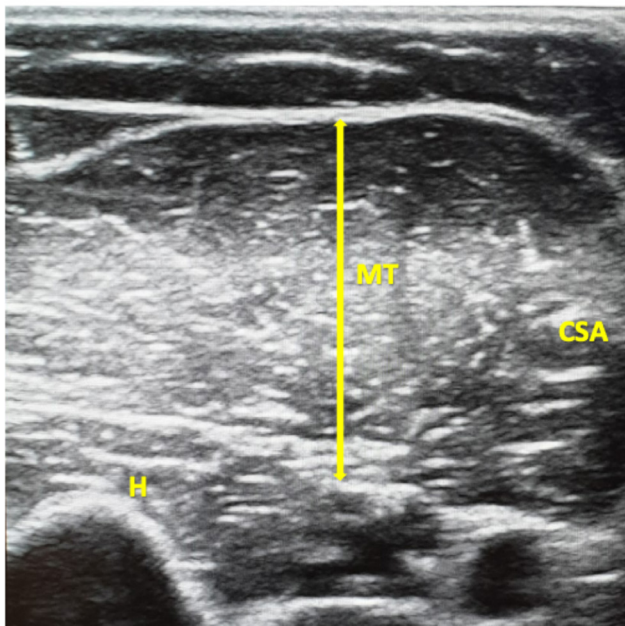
Transverse ultrasonographic image of biceps brachii muscle
